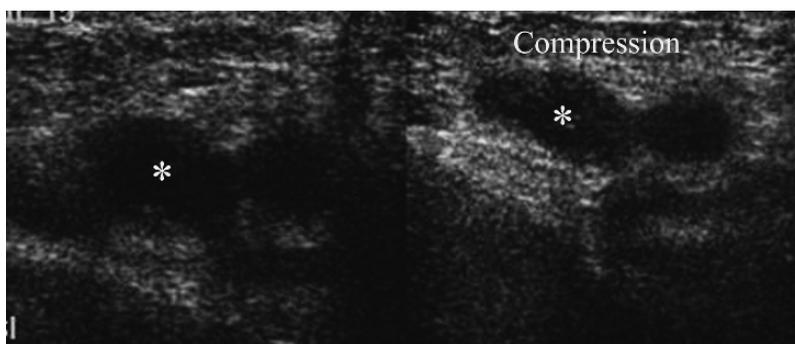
Ultrasound without (left) and with (right) compression demonstrates a noncompressible right common femoral vein (*) consistent with DVT.
